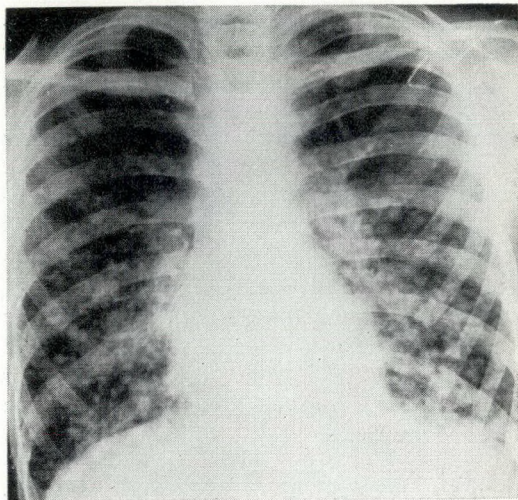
Radiographic appearance of Case 3 in November 1957.
